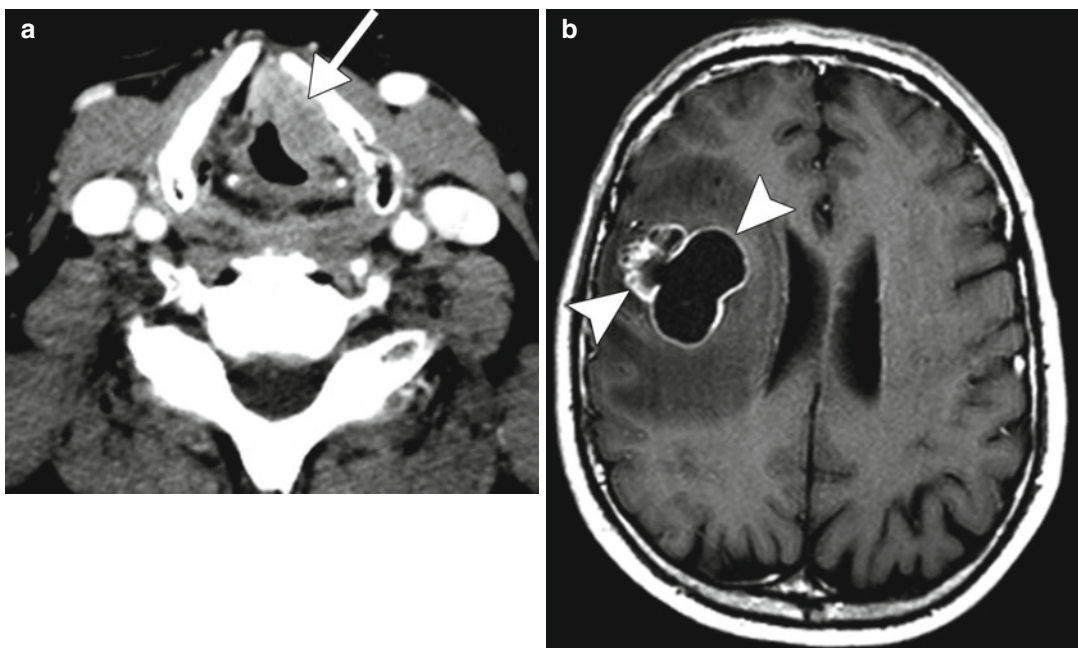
Laryngeal squamous cell carcinoma with brain metastasis. This 25-pack-year smoker had been recently diagnosed with laryngeal squamous cell carcinoma when he developed generalized seizures. Axial CT image (a) shows a
